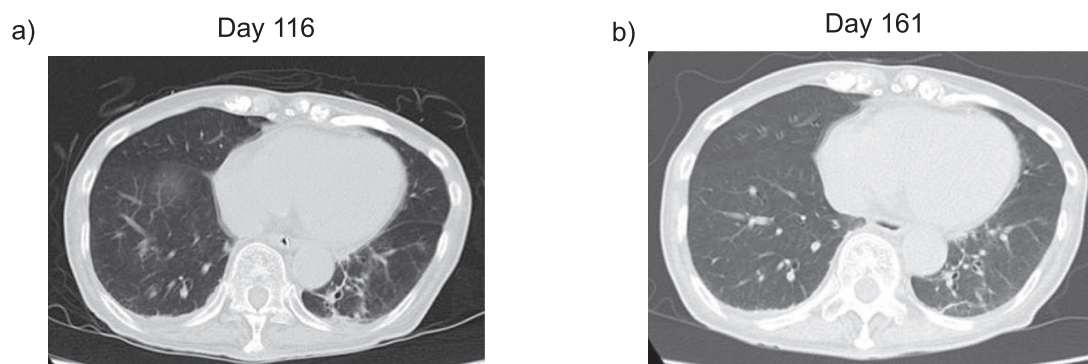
(a) Chest radiography findings on Day 116. CT showed improvement of interstitial lung disease. (b) Chest radiography findings on Day 161. CT showed slight improvement of interstitial lung disease.
